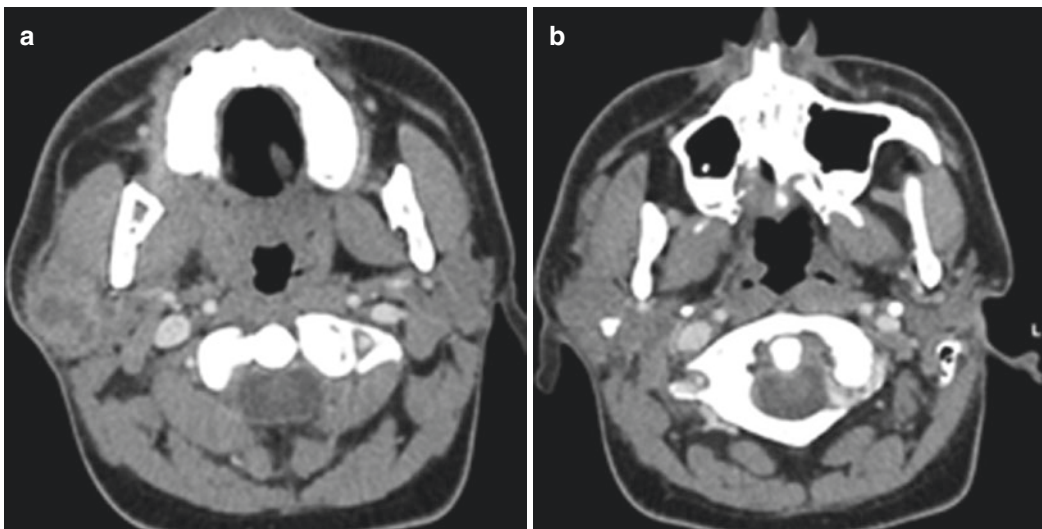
CT demonstrating right parotid stone (a) with developing abscess (b)
